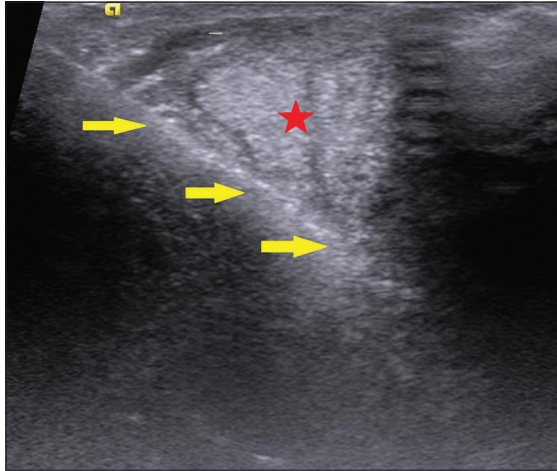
Ultrasound-guided biopsy of Achilles tendon lesion. The target was the hypoechoic area on the anterior aspect of Achilles tendon. (Yellow arrows: Biopsy needle trajectory, red asterisk: Achilles tendon). The targeted biopsy of the hypoechoic area was the advantage of image-guided biopsy over blind biopsy).
